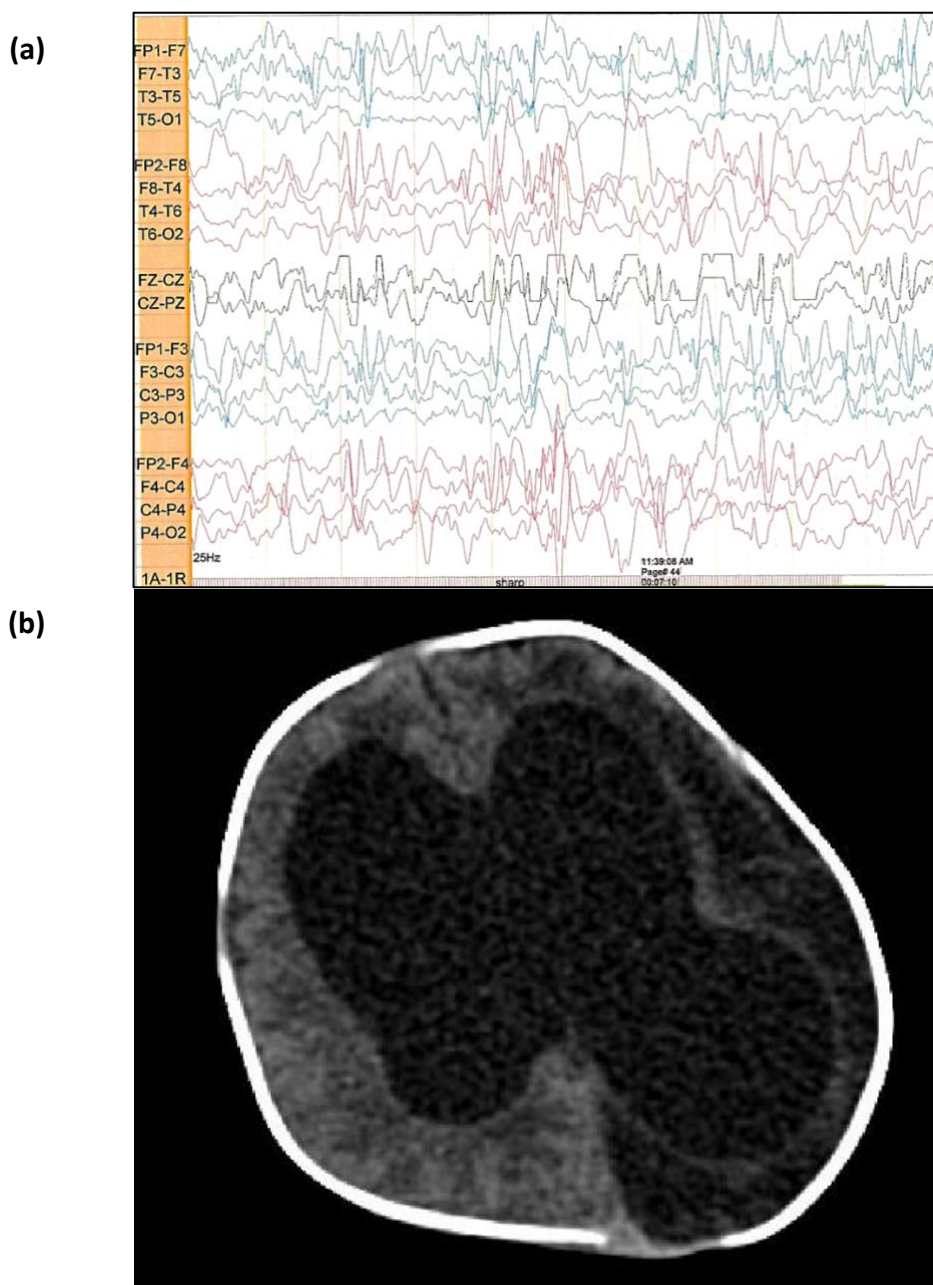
(a) The electroencephalogram (EEG) showed diffuse epileptogenicity with hypsarrhythmia; (b) brain CT scan showed ventriculomegaly, and encephalomalacia of both hemispheres, especially in the left parietooccipital.
